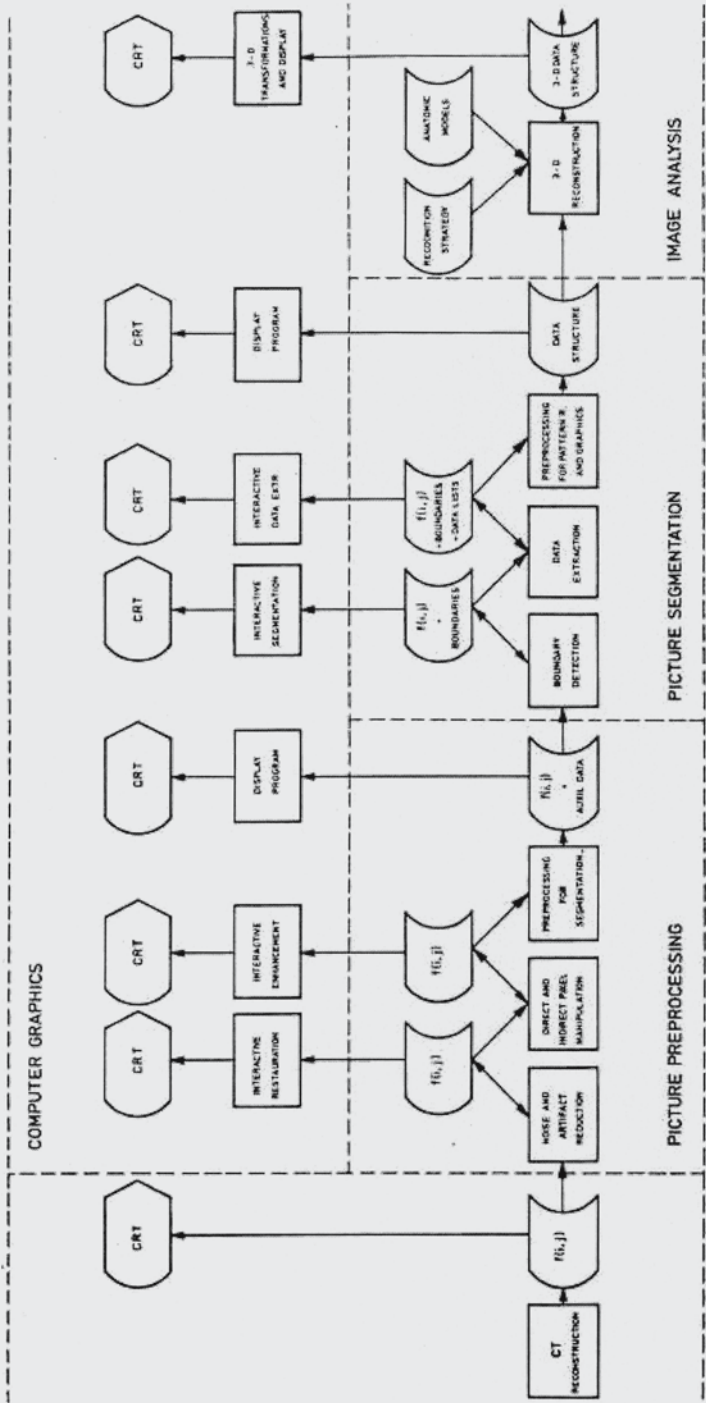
Data flow for the processing of computed tomograms
